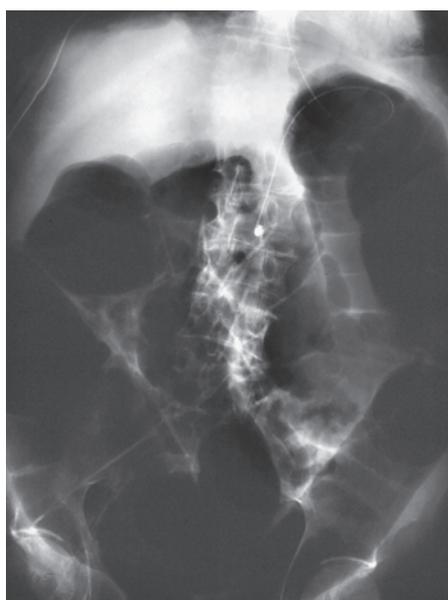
Pseudo-obstruction of the colon. Abdominal radiograph in a patient with sepsis syndrome on artificial respiration and with massive distention of the entire colon, especially the cecum (image provided courtesy of Dr. V. Remplik, Institute for Diagnostic Radiology and Neuroradiology, Augsburg Clinic).
